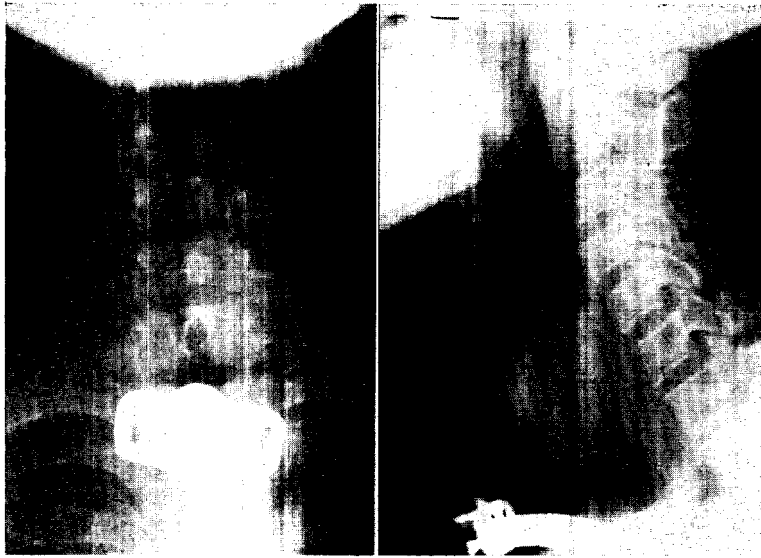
Case 2.—Anteroposterior and lateral roentgenogram showing, in the first, almost complete obliteration of the tracheal air column and in the second, the large tumor mass extending posteriorly.
